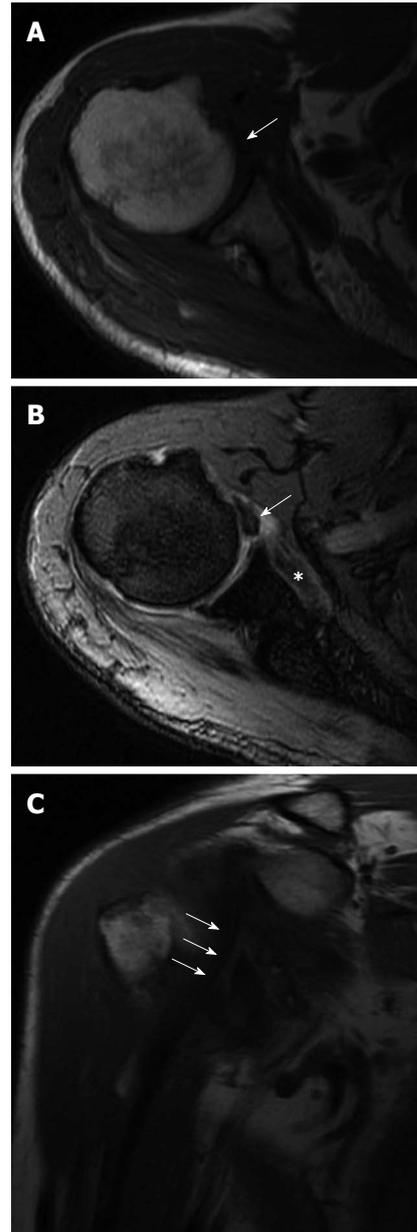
Subscapularis tendon avulsion with long head of biceps tendon dislocation. A: Axial T1-weighted image; B: Axial gradient-recalled echo image; C: Coronal oblique T1-weighted images showing avulsion of the subscapularis tendon (asterisk in B) with muscular atrophy and long head biceps tendon dislocation (arrows) with diffuse tendinous thickening and high signal.
